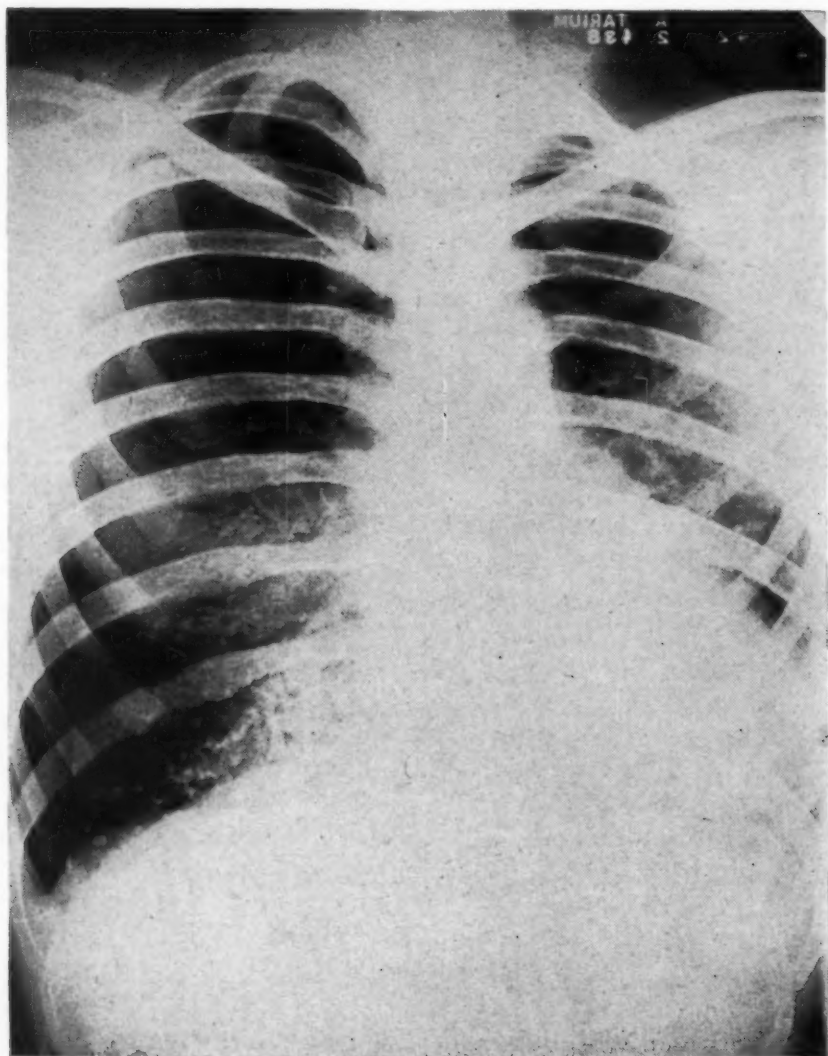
Antero-posterior roentgenogram of the chest showing partially collapsed left lung with an adherent pleura and also right pneumothorax with a free pleural space, following a left artificial pneumothorax.
